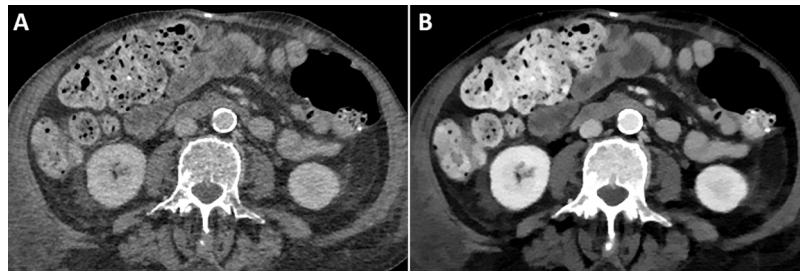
92-year-old male with poor venous access undergoing aortic CT angiography at an iodinated contrast administration rate of 3 ml/s. (A) Axial image resulting in suboptimal venous phase. (B) Virtual monoenergetic image at 45 keV, significant improvement of vascular opacification.
